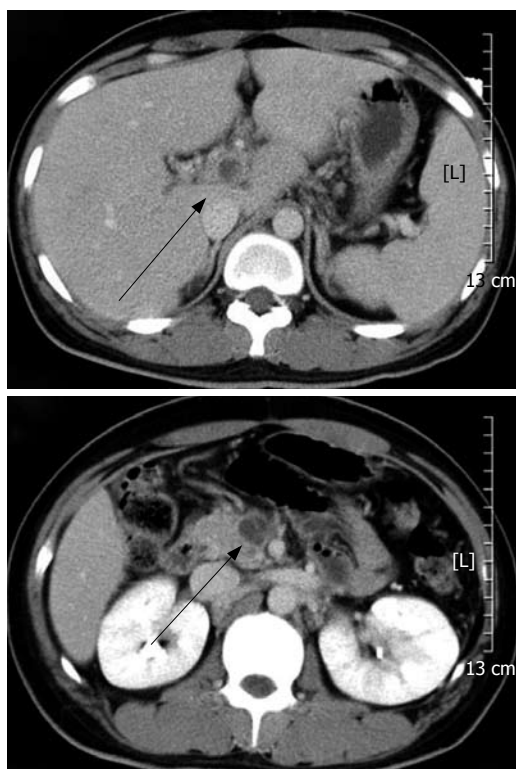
CT scan showing total occlusion of the portal vein with a thrombus (arrow) extending to the superior mesenteric vein.
